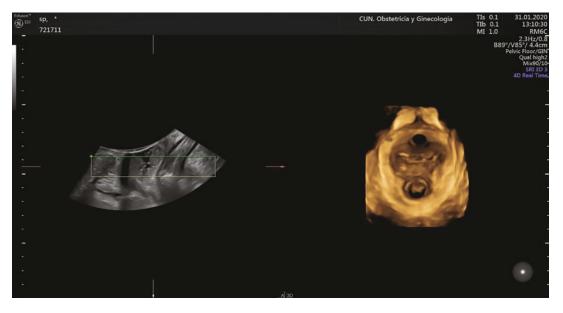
2D ultrasound and 3D reconstruction of the axial plane (rendered volume technique). The left-hand panel shows the midsagittal plane, the right-hand panel is
